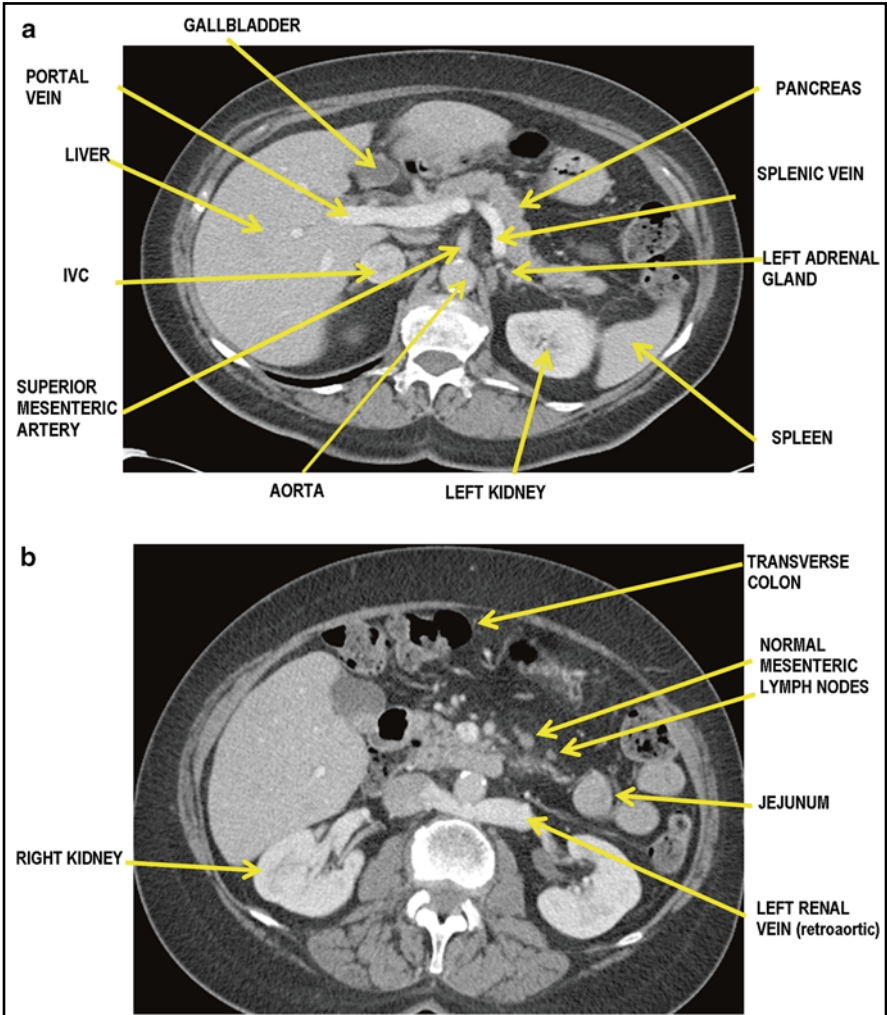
NORMAL ANATOMY ON CT
